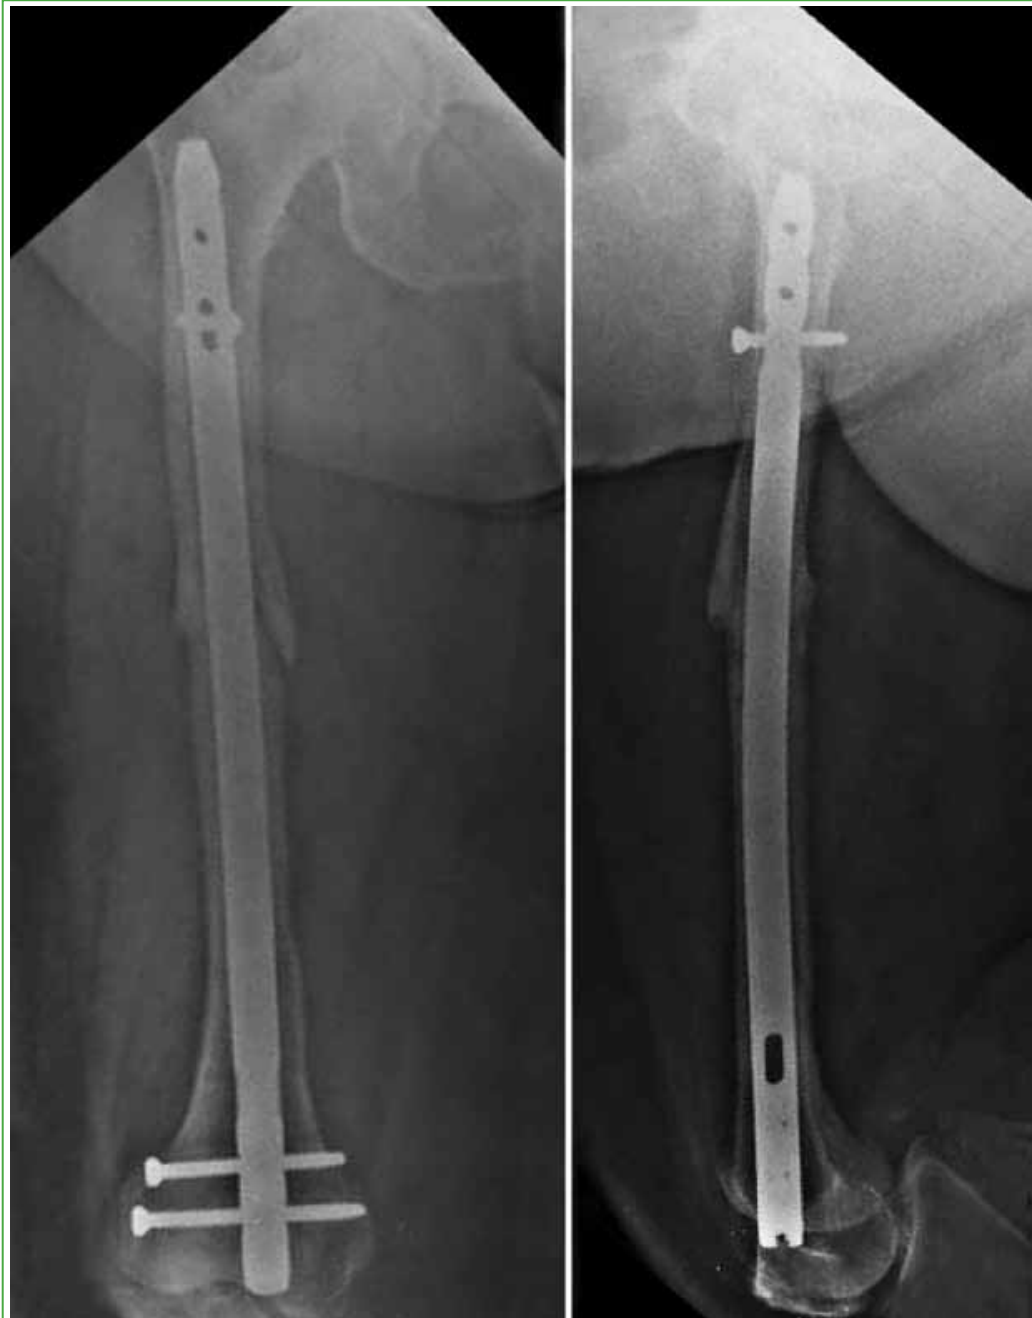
Radiographic control 5 months after surgery. There are signs of bone consolidation.
